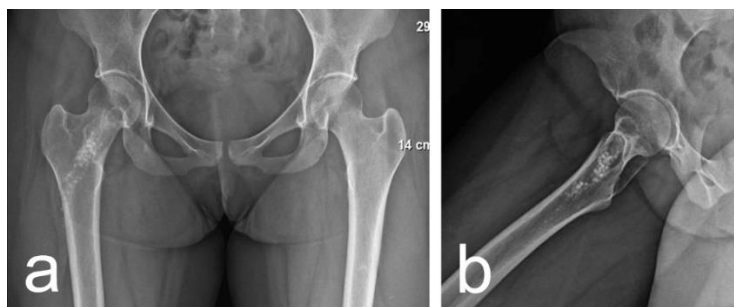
Postoperative roentgenography on the sixth month after operation.
